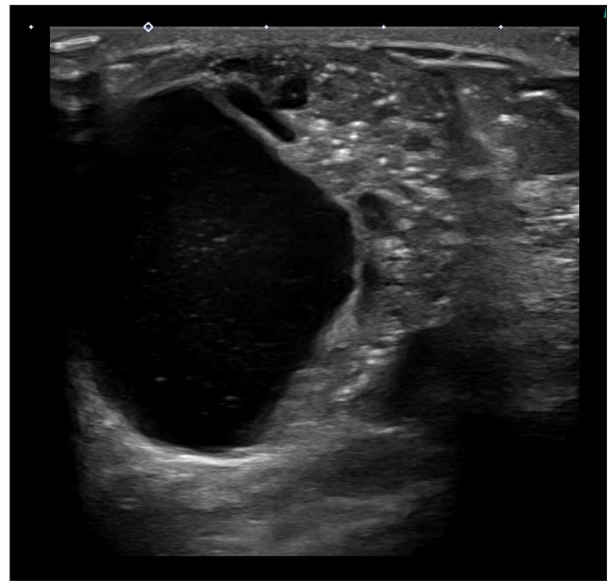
Invasive cribriform carcinoma on breast ultrasound. Breast ultrasound shows a large complex cystic and solid mass with multiple calcifications within the solid portion.
